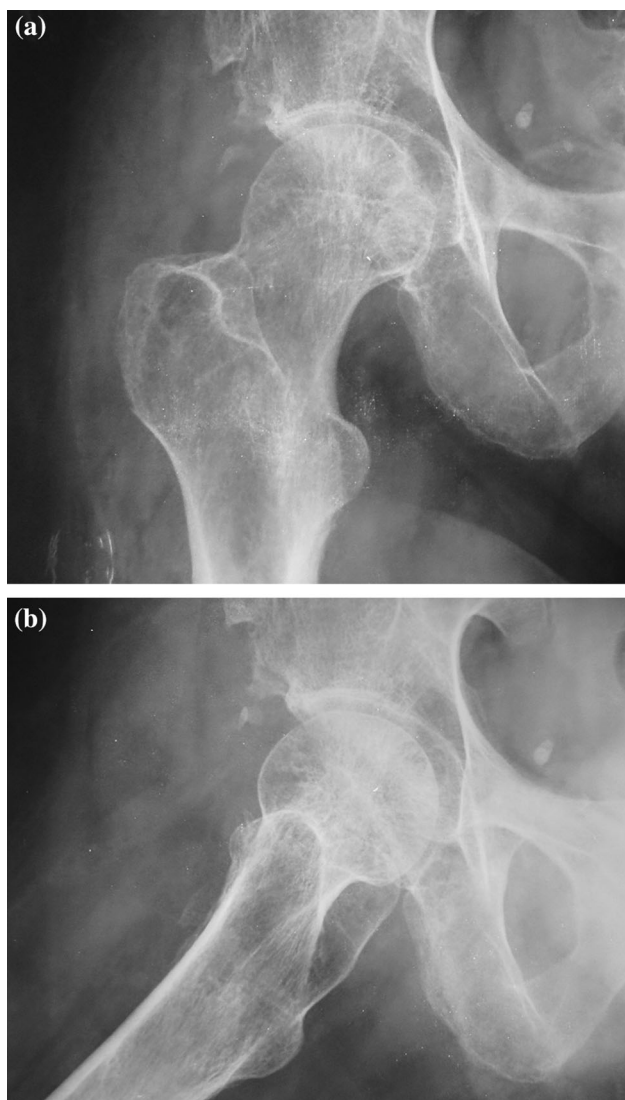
a, b Postoperative X-rays of the same patient, 32 months after surgical resection of HO
